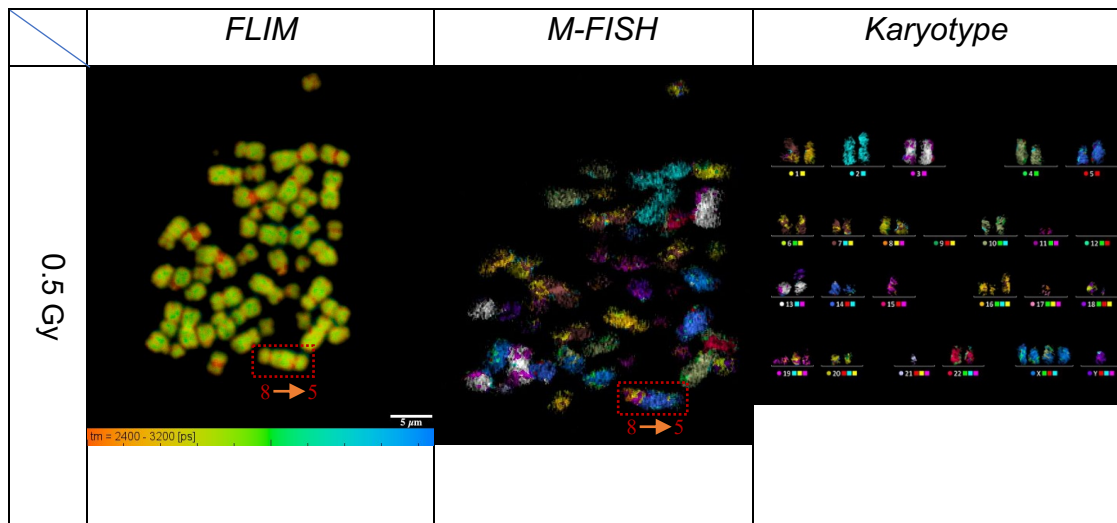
A spread irradiated at a 0.5 Gy X-ray exposure. The red dotted box represents translocation of q-arm of chromosome 8 into the q-arm of chromosome 5, shown in both FLIM and M-FISH image. Scale bar= 5 μ m.
